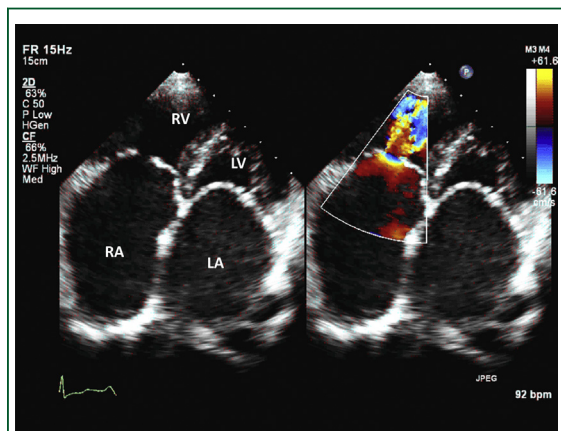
Apical 4-chamber view from a patient with tricuspid stenosis showing doming of the tricuspid valve and turbulent color flow across it. Note that this patient also has mitral stenosis. Abbreviations as in Figures 1 and 2.
